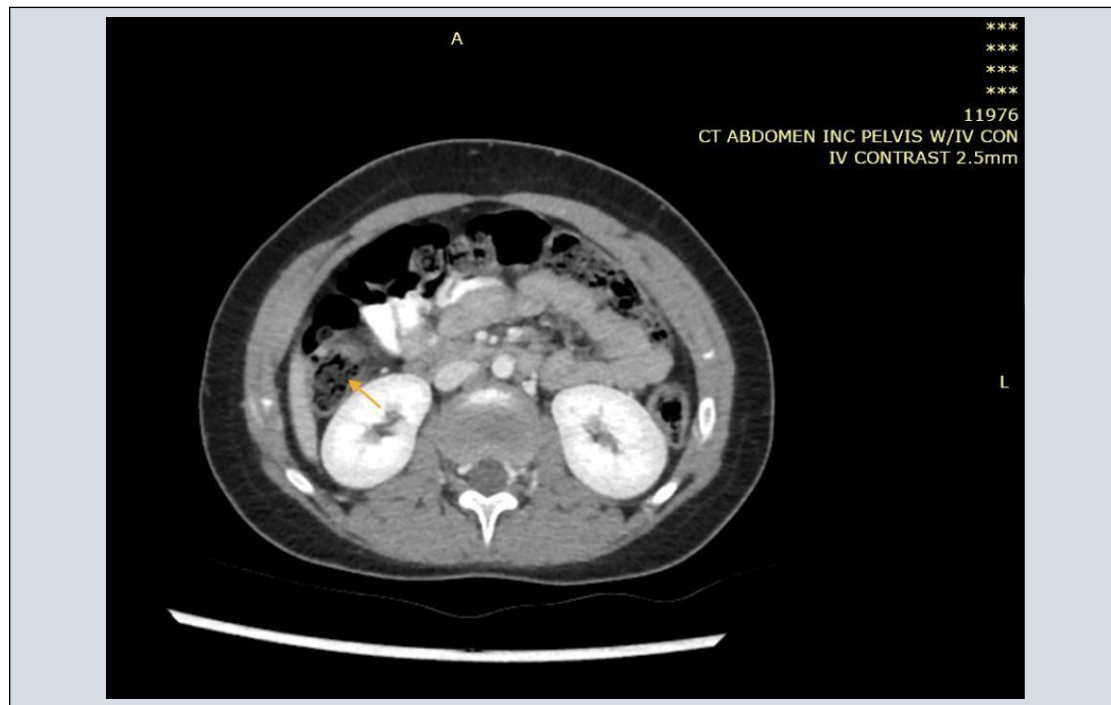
Repeated CT scan of the abdomen with iv contrast compared with previous study near total disappearance of the previously noted colonic and ileal masses (orange and yellow arrows), now mild residual thickening is seen in the secum and terminal ileum, few residual lymph nodes are noted.
